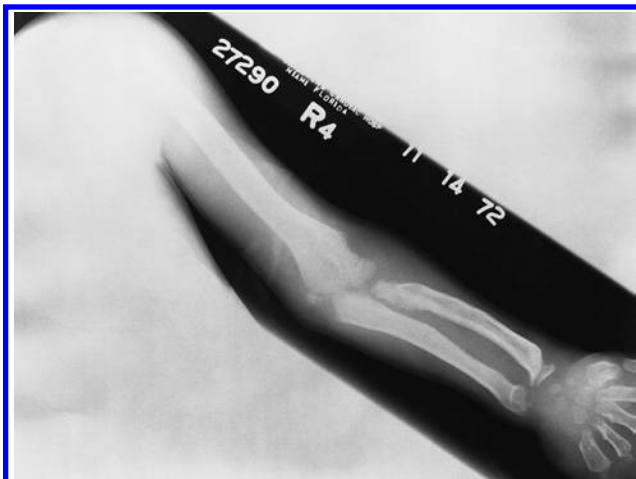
Roentgenogram of the radius and ulna of a patient with mucopolipidosis III.
